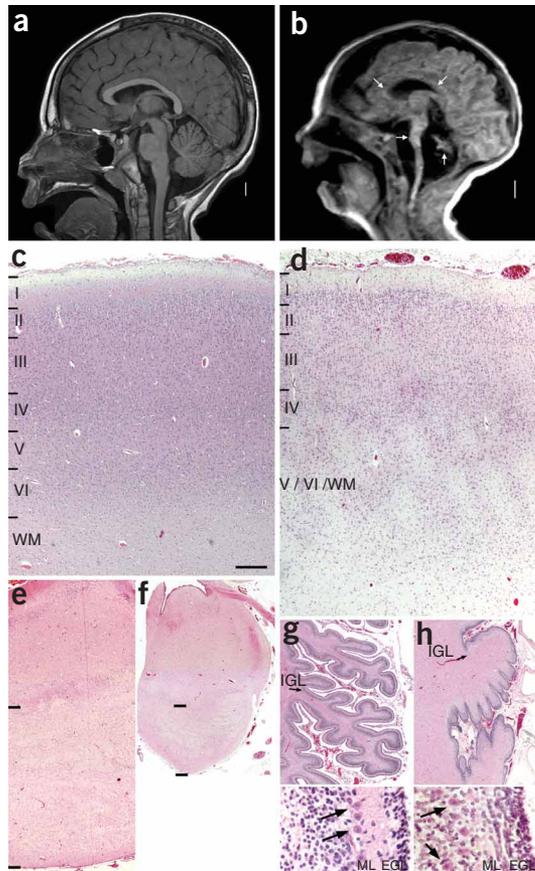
Brain imaging and pathologic features in a boy with the *CASK* 915G>A mutation (individual 5). (a,b) Compared to a normal control brain (a), magnetic resonance images in individual 5 (b) show a thin and unmyelinated corpus callosum (angled arrows) and severe hypoplasia of the brainstem (horizontal arrow) and cerebellum (vertical arrow). (c,d) The frontal cortex (d) is moderately disorganized and mildly thickened compared to an age-matched control (c). Cortical laminae I–IV appear normal, whereas layers V and VI merge together and show a vaguely nodular organization. These layers subtly merge into the white matter (WM), which differs from the well-defined border between layer VI and WM in the control cortex. (e,f) The pons is markedly reduced in size in the affected boy (f) compared to a control (e) because of loss of neurons in the basis pontis (borders defined by black lines). (g,h) The cerebellum (h) shows poorly formed, shallow and unbranched folia when compared to an age-matched control (g). In contrast to the normal external granular cell layer (EGL) in the age-matched control cerebellum (g, bottom panel), the EGL is abnormally thick in the cerebellum of individual 5 (h, bottom panel), and the internal granular cell layer (IGL) virtually absent (compare g and h). Purkinje cells are evenly spaced, forming a single layer in normal brain (arrows in g, bottom panel). In contrast, Purkinje cells in individual 5 are not seen in a single row (arrows in h, bottom panel). The bottom panels of g and h also show hypercellularity in the molecular layer (ML) and increased thickness of the EGL in individual 5 (h, bottom panel). Scale bar in c (lower right corner): 250 μ m (c,d), 500 μ m (e–h), 50 μ m (bottom panels of g and h).
